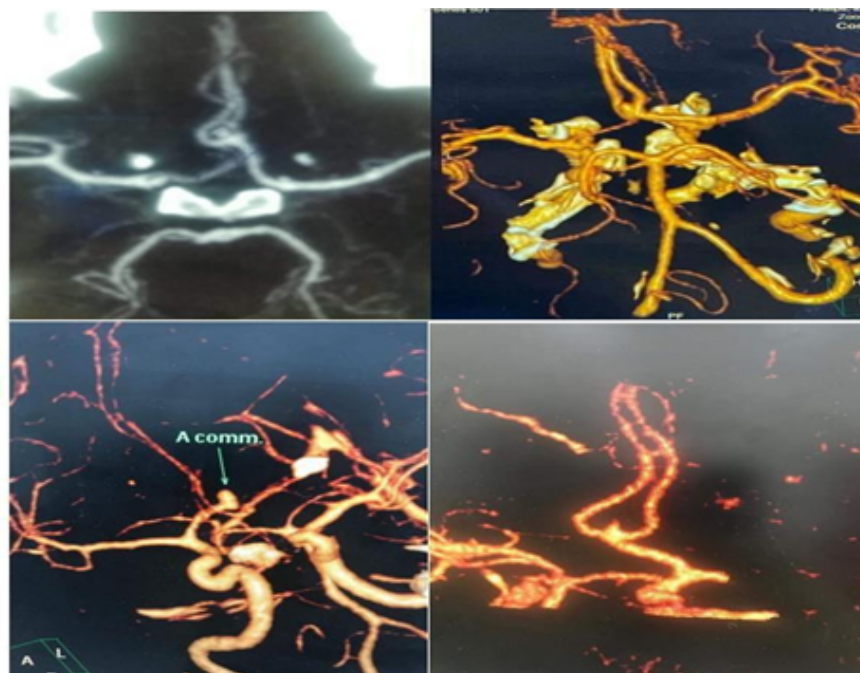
CT Angiography of Acom Aneurysms.
